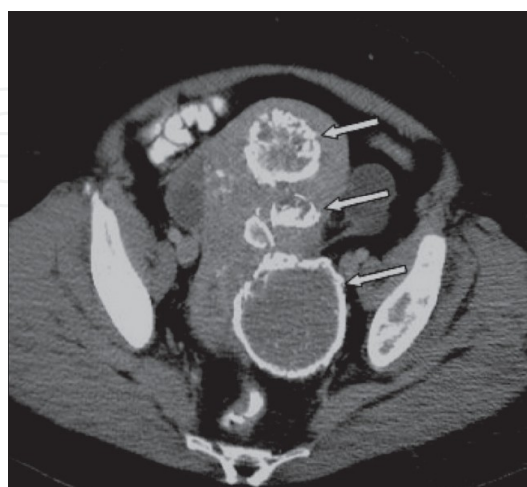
CT scan showing multiple uterine fibroids.(Arrows). Wilde Sue and Scott-Barrett Sarah. Radiological appearances of uterine fibroids. Indian J Radiol Imaging. Aug 2009; 19(3): 222–231.
